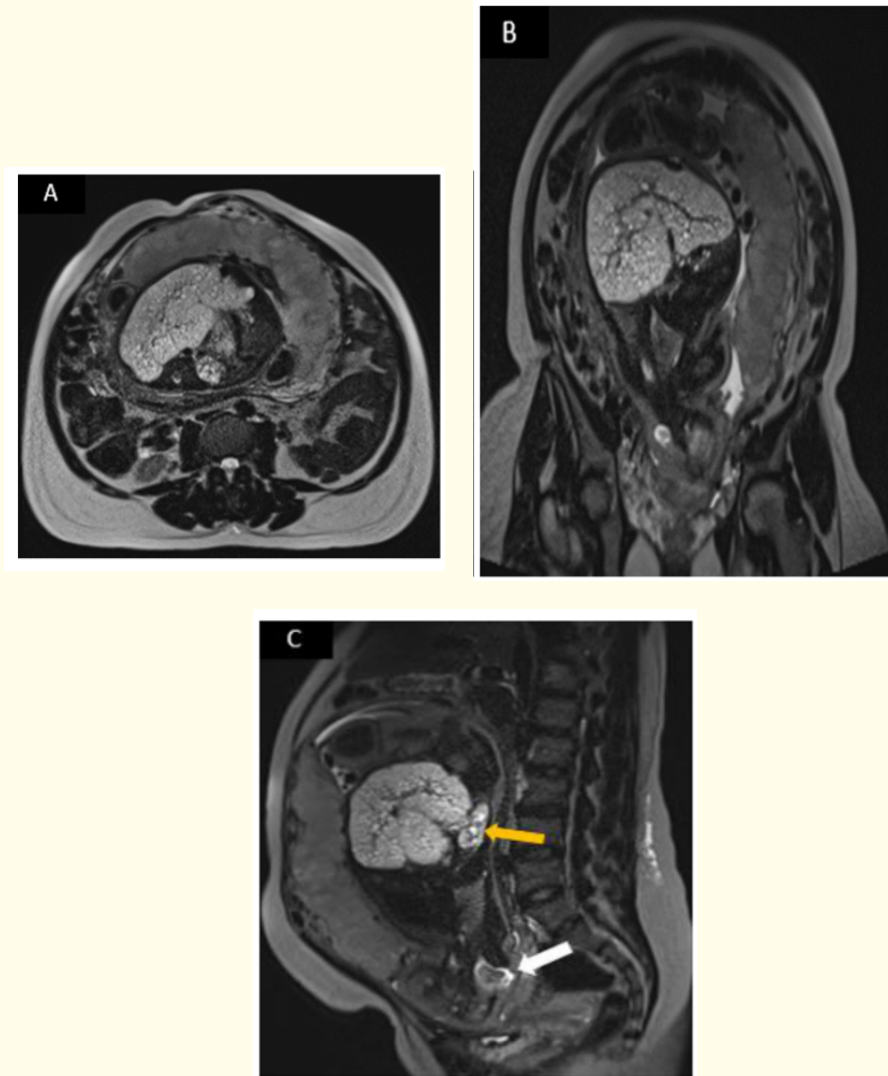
Fetal MRI in T2 axial (A) Coronal (B) and sagittal (C) sequences showing a cephalic position fetus with a large left kidney occupying the entire abdominal cavity, with the parenchyma replaced by microcysts. The right kidney (Yellow arrow) is of normal size with the same characteristics. Microcephaly with occipital myelomeningocele (white arrow).
